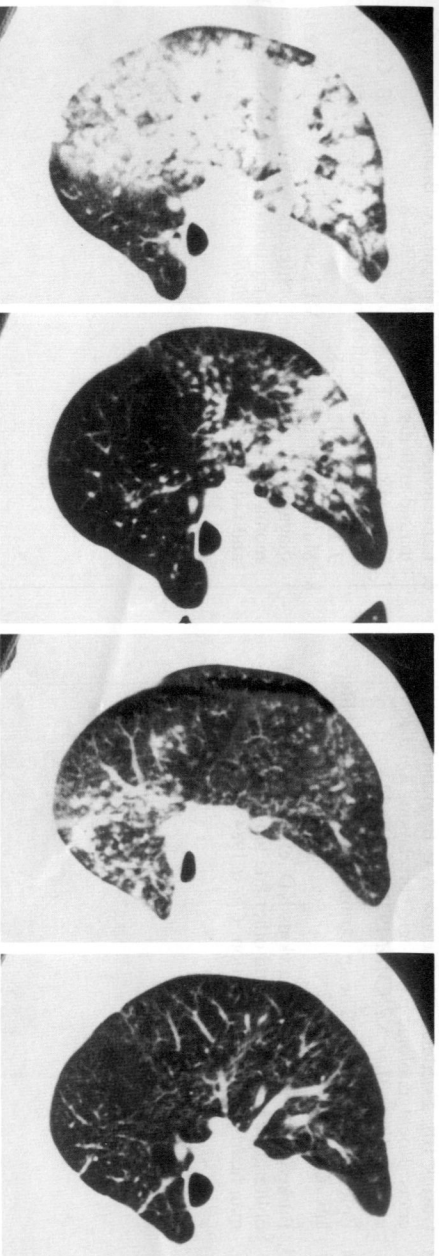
High resolution CT (HRCT) of the right chest at the level of midlung viewed at window levels appropriate for pulmonary parenchyma (level - 600 HU, width 1,200 HU). a: Two days after admission, HRCT scan reveals segmental alveolar opacities with air bronchograms. b: Eight days after admission, 6 days after the initiation of steroid therapy (methylprednisolone 1,000 mg for 3 days), HRCT scan shows marked improvement. c: Two months after admission, HRCT reveals alveolar opacities and patchy areas of consolidation in the right lower lobe, which had been spared at first. The next day open lung biopsy was performed. d: Three and one-half months after admission, HRCT scan shows almost complete resolution of the abnormal shadow by steroid therapy.
